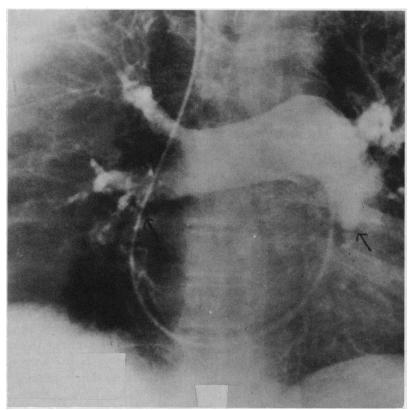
Pulmonary angiogram of the same patient whose chest x-ray and lung scan are shown in Figures 1 and 3. Note the marked reduction in pulmonary arterial blood flow to the entire right lung and left lower lobe.
